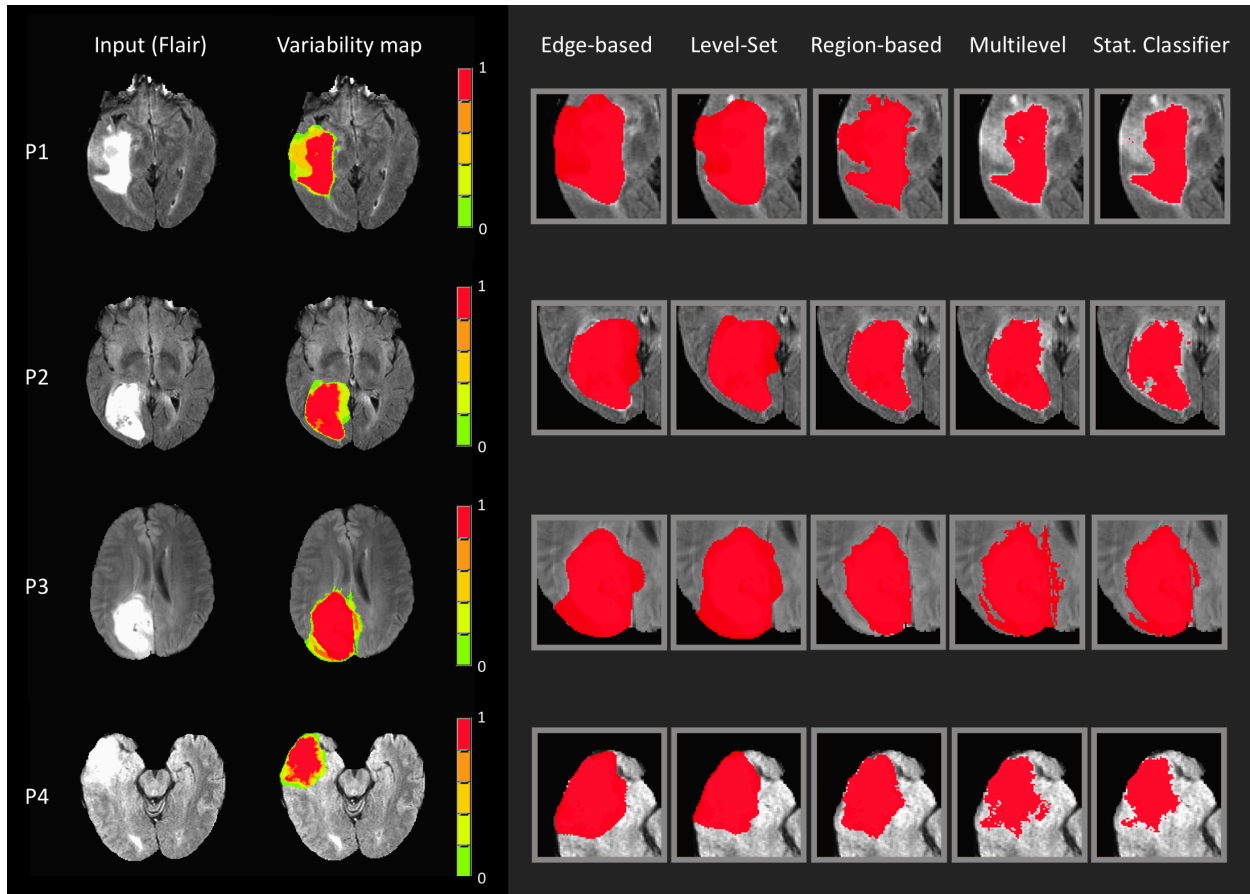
Examples (FLAIR) of tumor measurement variability maps generated using different algorithms. The first two columns on the left show the input image and resulting tumor variability map. The other columns on the right show the individual components of the variability map provided by the different algorithms.
